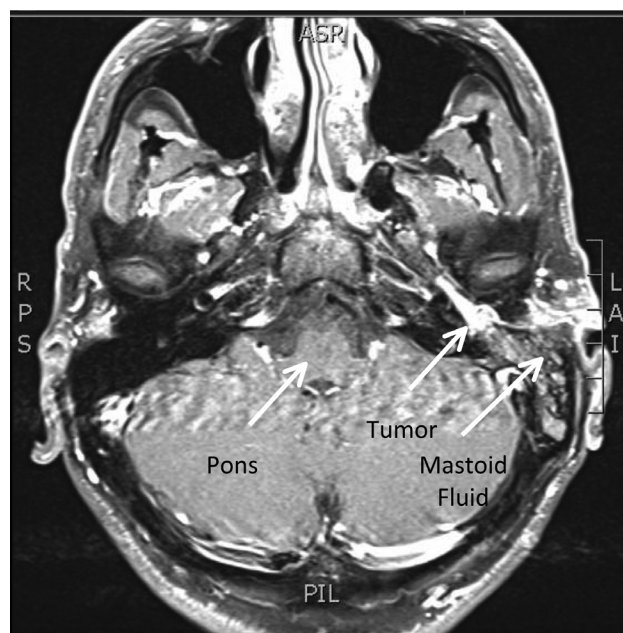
This axial gadolinium-enhanced T1-weighted MRI of the internal auditory canals shows enhancement of the tumor in the middle ear and the tumor's extension into the mastoid.
